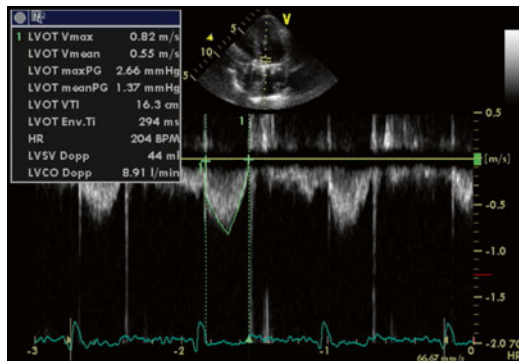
Left Ventricular Outflow Tract (LVOT) Pulsed Wave (PW) Doppler position 2 (moved more apically to avoid flow convergence and acceleration of flow and falsely elevated LVOT velocity)
